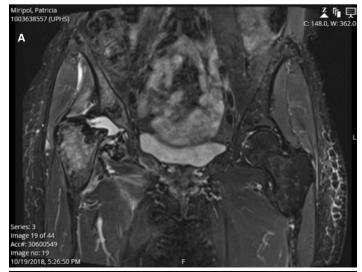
MRI obtained approximately 15 weeks following the right hip injection; (A) coronal plane view of a short tau inversion recovery (STIR) MRI of the pelvis showing complete destruction of the right femoral head with associated bone marrow edema in the proximal femur, hip joint effusion, and intramuscular edema; (B) axial plane view of a T1 fat saturated MRI of the right hip redemonstrating the destruction of the femoral head as well as a loculated intramuscular fluid collection.
